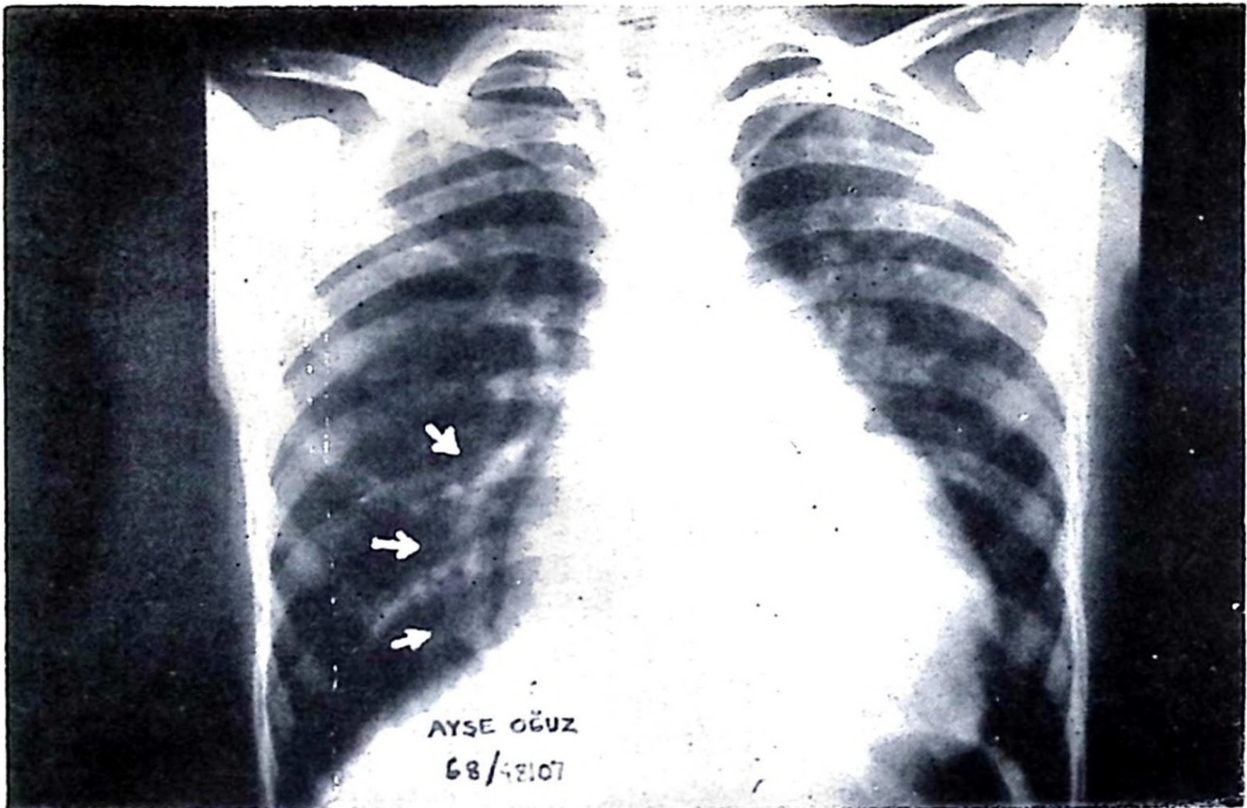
Posteroanterior chest roentgenogram (Arrows indicate the scimitar-shaped shadow).
